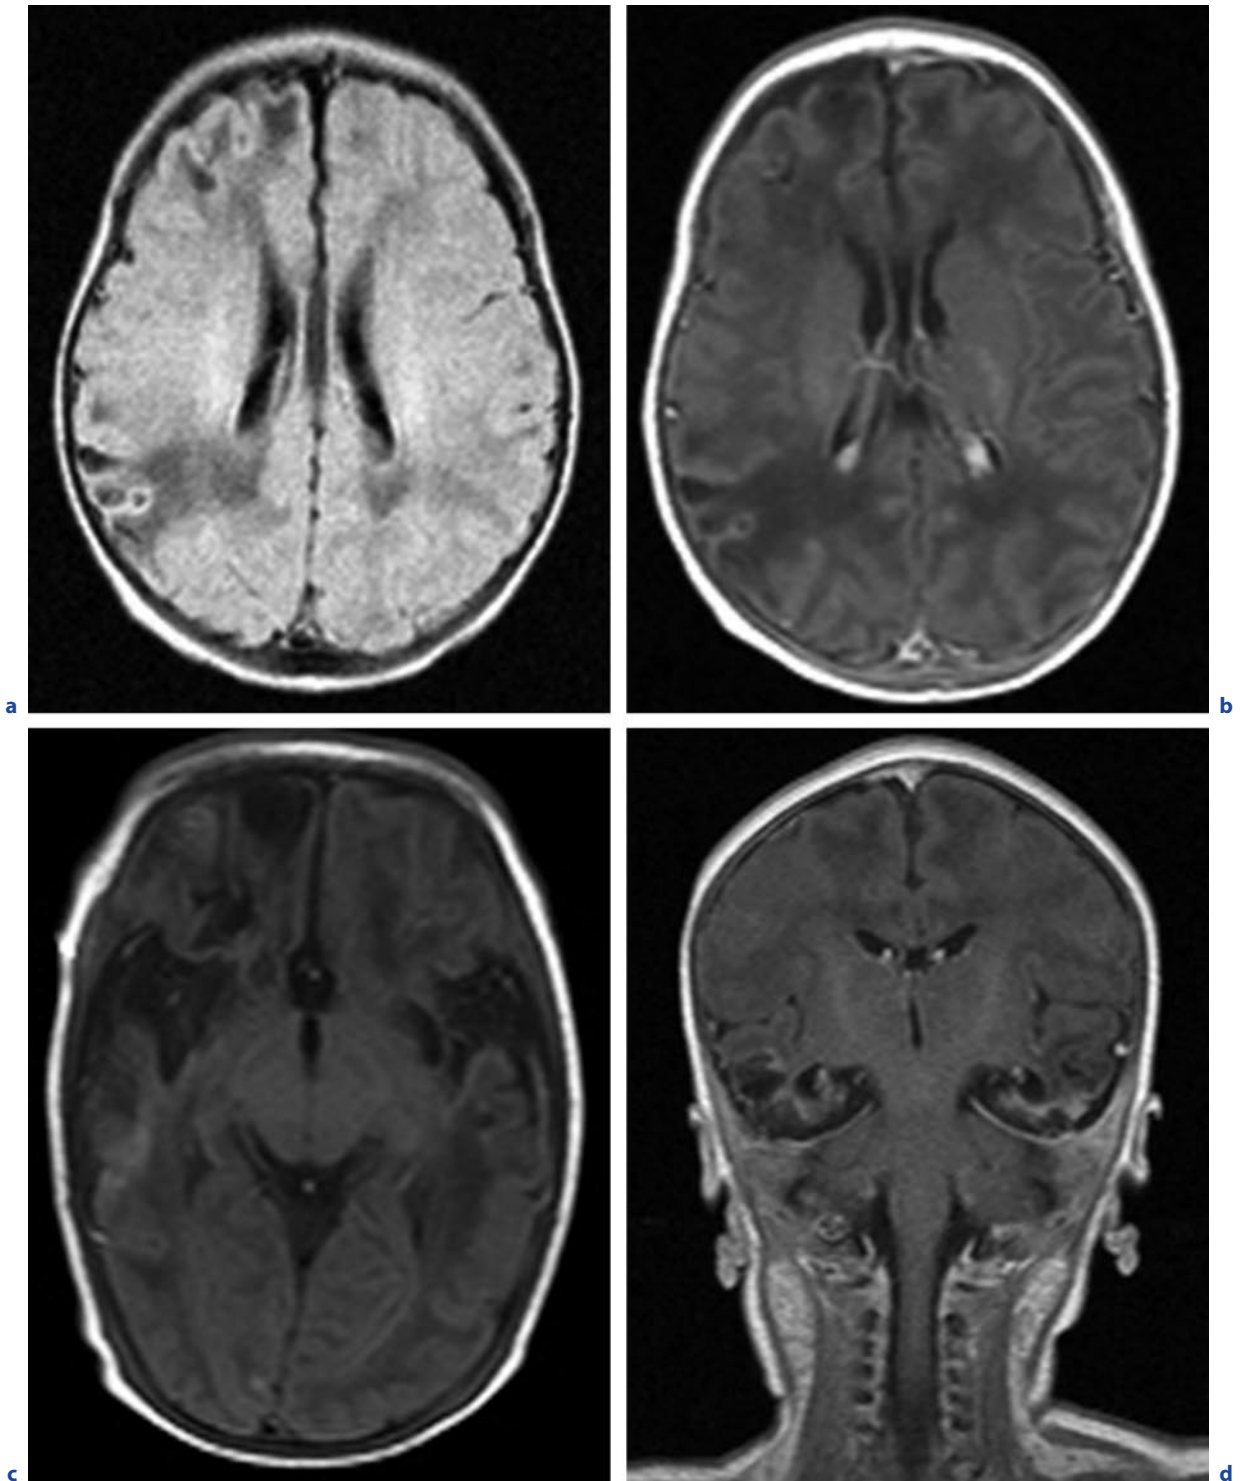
Neonatal HSV type-II encephalitis in a 3-week-old girl. a Axial FLAIR image. b,c Axial T1-weighted images after contrast administration. d Coronal T1-weighted image after contrast administration. Areas of oedema as well as areas of haemorrhage and atrophy
